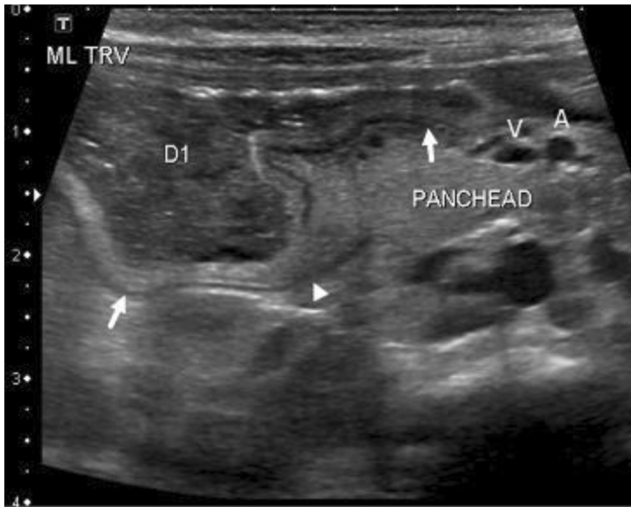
1-day-old baby girl with atresia of the first portion of the duodenum (D1). Transverse ultrasound image of the upper abdomen demonstrate thickening and hyperechogenicity of the stomach and duodenum (arrow) and an abrupt stop of D1 (arrowhead). Note the normal relationship of the superior mesenteric artery (A) and vein (V)
